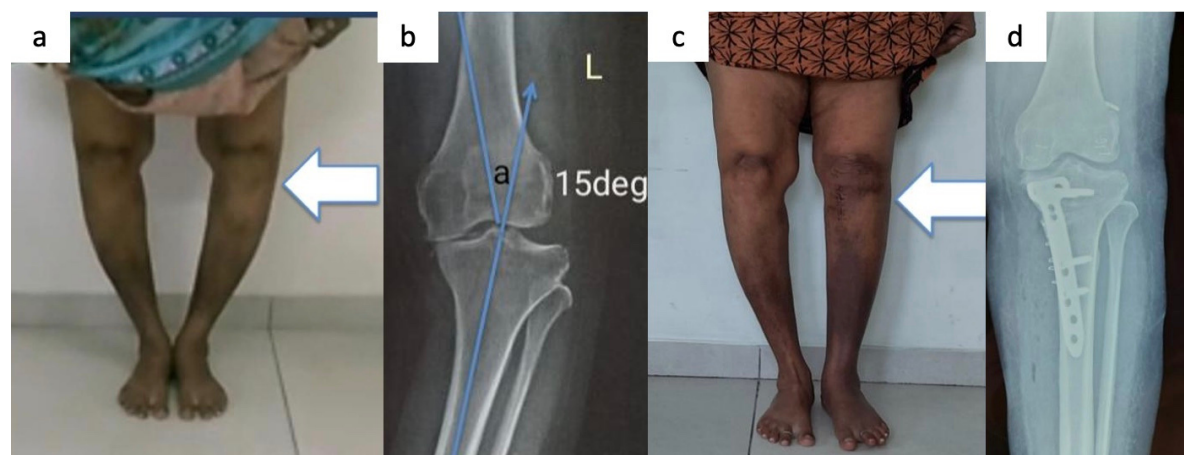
Pre-operative & post-operative images. A & B: Pre-operative clinical image & Alignment radiographs B: Post-operative clinical image & Alignment radiographs
